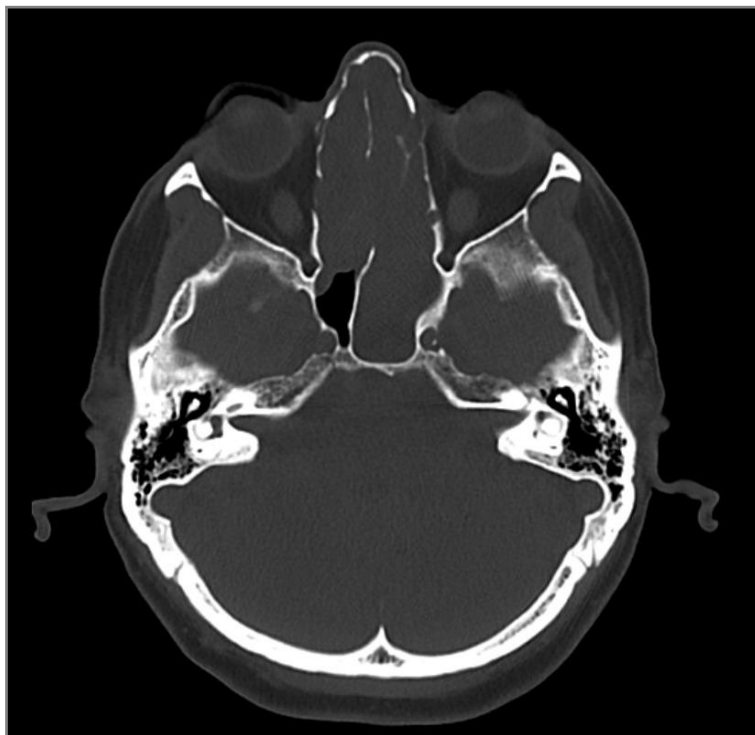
CT (axial section) of a patient with CRSwNP, operated on multiple times, with recurrence of NP.
